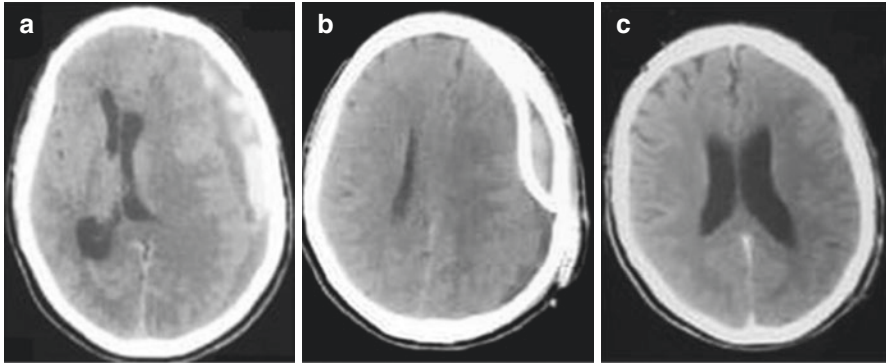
(a) Initial brain CT scan demonstrating left CSDH with acute rebleeding. (b) Immediate postoperative CT scan showing the drain position. (c) Late CT scan demonstrating total resolution of the CSDH
